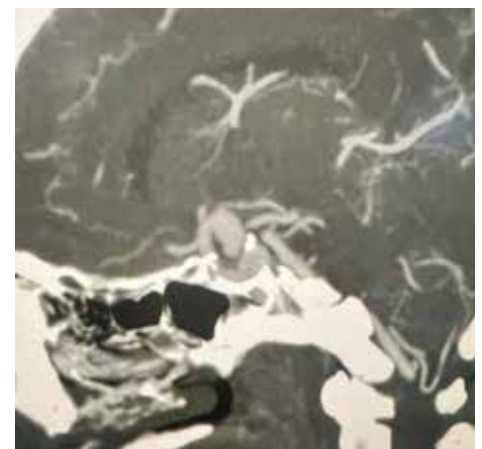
Sagittal CTA demonstrating wide neck right posterior communicating artery aneurysm
